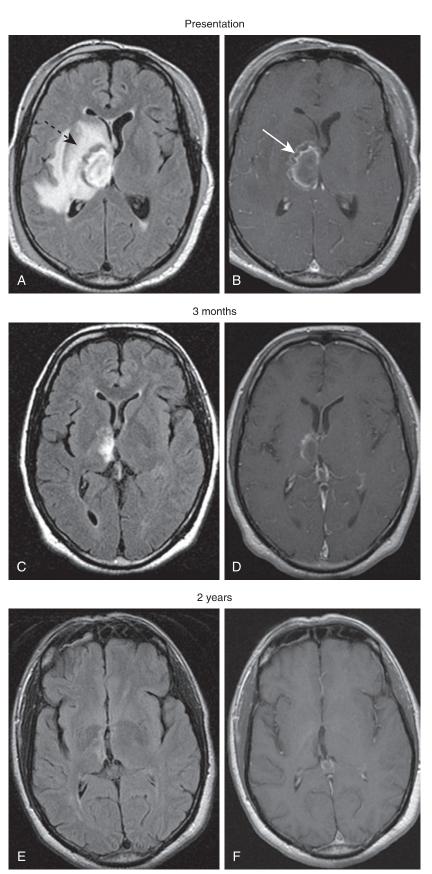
CNS toxoplasmosis mimicking tumor. Serial brain MRI images in a patient with CNS toxoplasmosis. Top row: Axial T2 FLAIR (A) and postcontrast T1 (B) images at time of presentation demonstrate a large rim enhancing right thalamic lesion (arrow) with extensive surrounding T2 hyperintensity (dashed arrow). Middle row: At 3 months after initiation of therapy, axial T2 FLAIR (C) and postcontrast T1 (D) images demonstrate marked decrease in size of the right thalamic enhancing lesion with improvement of surrounding vasogenic edema. Bottom row: At 2-year follow-up axial T2 FLAIR (E) and postcontrast T1 (F) images demonstrate resolution of enhancement with residual encephalomalacia at the site of the prior lesion. (Images courtesy Divya Bolar, MD, PhD, Massachusetts General Hospital, Boston.)
